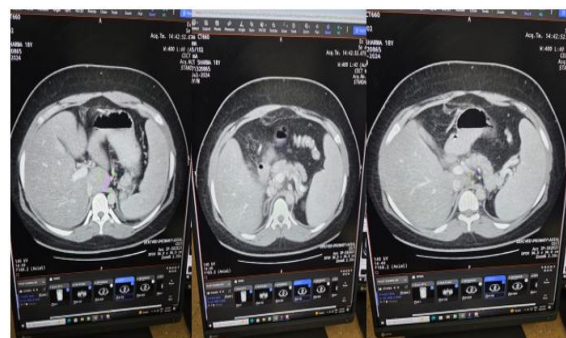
Axial views of contrast enhanced computed tomography scans of abdomen showing bulky head of pancreas with adjacent peri pancreatic fat stranding s/o acute pancreatitis
